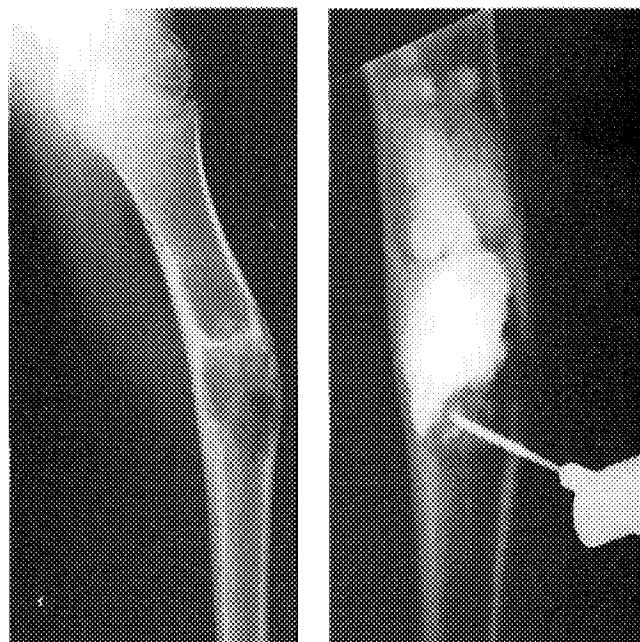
Left, Lateral radiograph of the proximal humerus, showing a cystic lesion consistent with a unicameral bone cyst. Right, The injection of contrast medium into the lesion, showing containment in a bicameral lesion.
